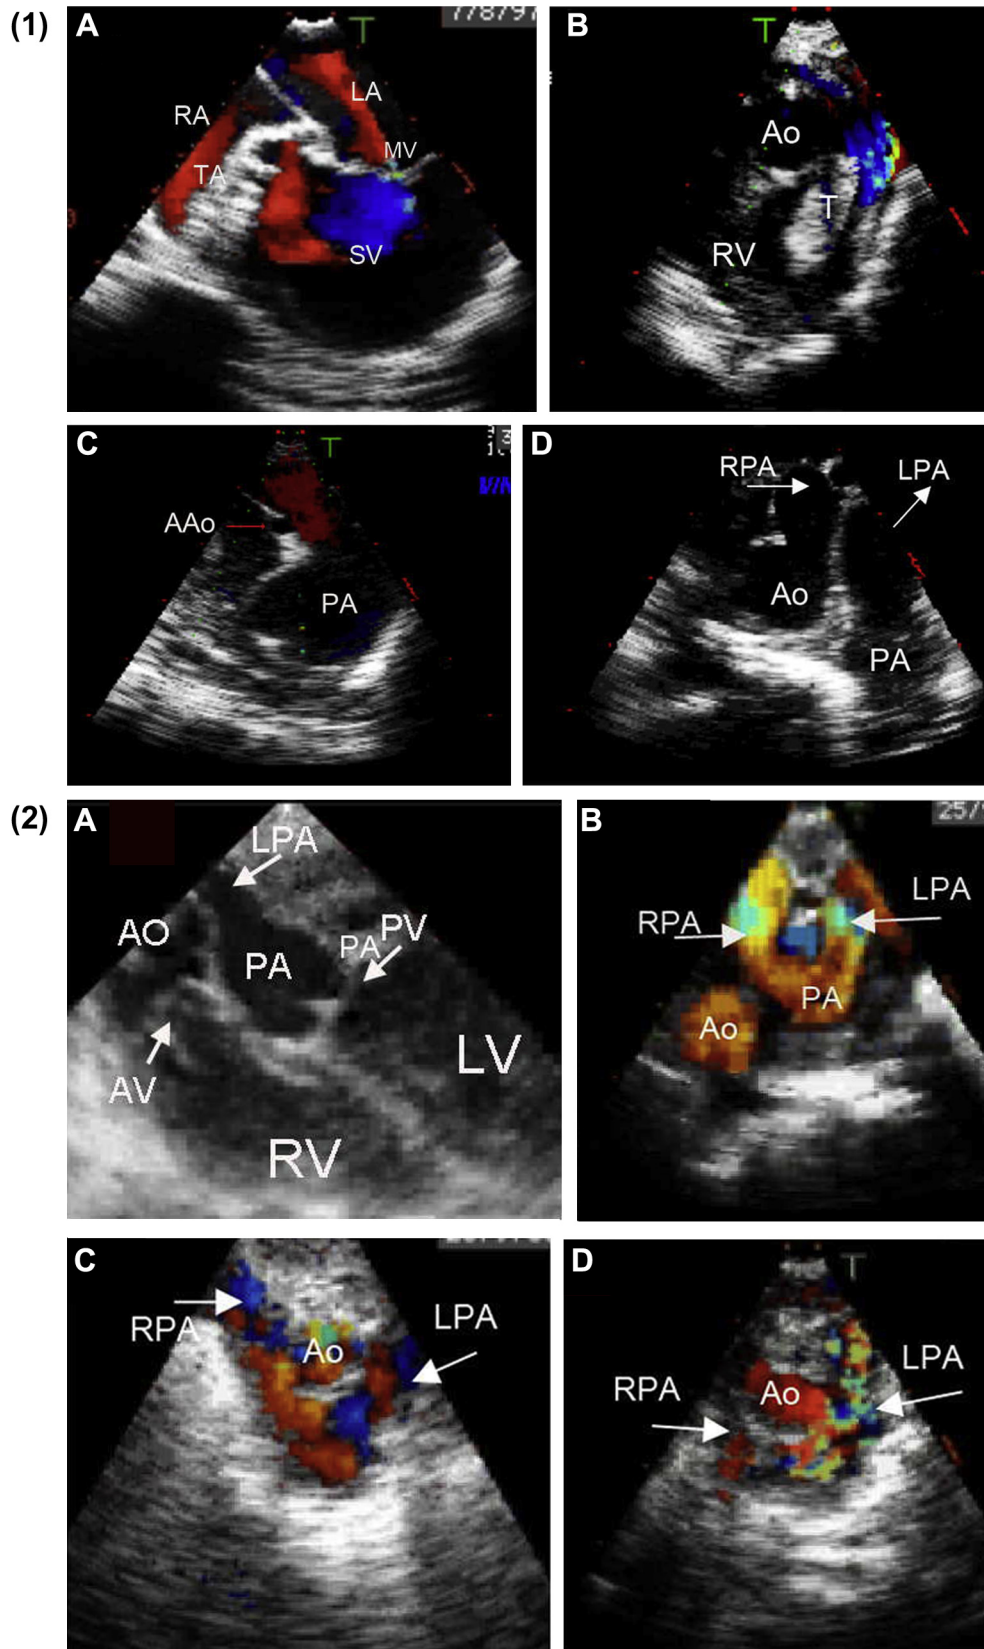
(1) Newborn infants with complex congenital heart diseases. (A) Two-dimensional (2D) echocardiogram (apical 4-chamber view) in an infant with tricuspid atresia (TA) shows a complete absence of the tricuspid valve, right atrioventricular connection, and single ventricle; (B) four-chamber view in an infant with a rhabdomyoma of the heart shows echogenic mass (T) attached to the interventricular septum and reducing the size of the outflow tract; (C) an infant with hypoplastic left heart syndrome demonstrates a hypoplastic aorta (Ao) and a huge pulmonary artery (PA); and (D) an infant with hemitruncus arteriosus shows the right PA (RPA) originating from the ascending Ao (AAo) and the left PA (LPA) from the pulmonary artery (PA). (2) A newborn with transposition of great arteries
